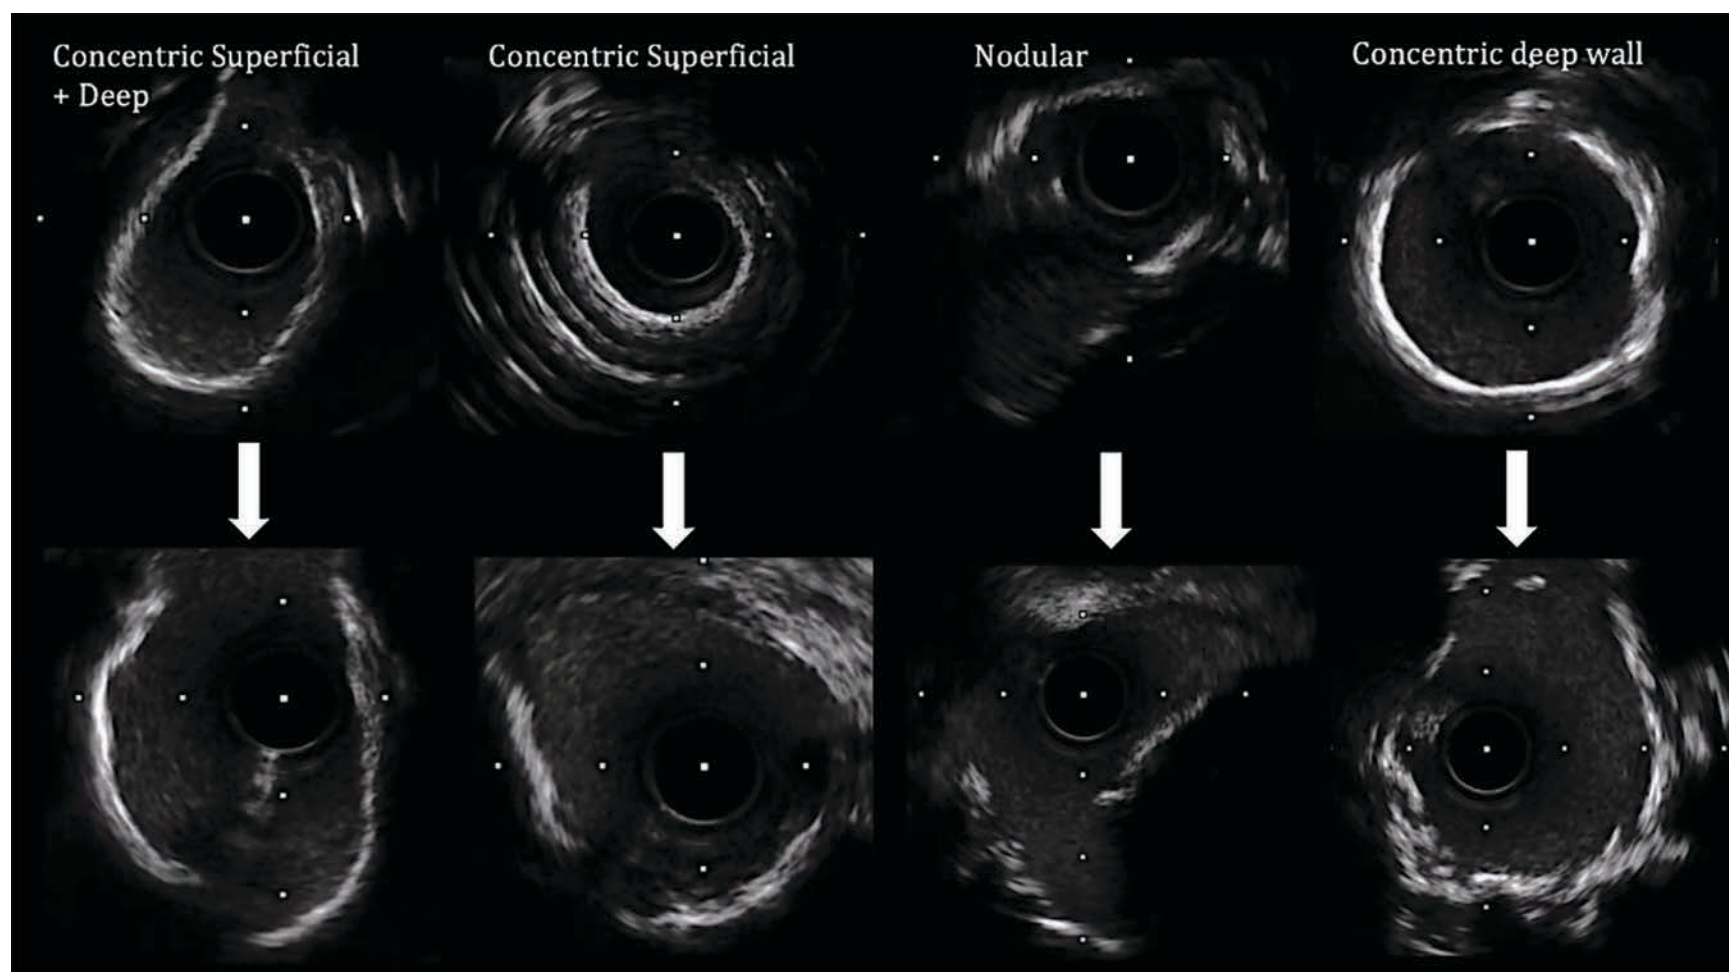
Intravascular ultrasound image panel. (Top) Before and (bottom) after inotrope-supported calcium modification with 4.0 IVL balloon catheter (Shockwave Medical).
